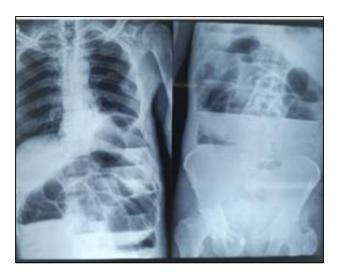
Chest and abdominal x-rays of the patient's preoperatively.
